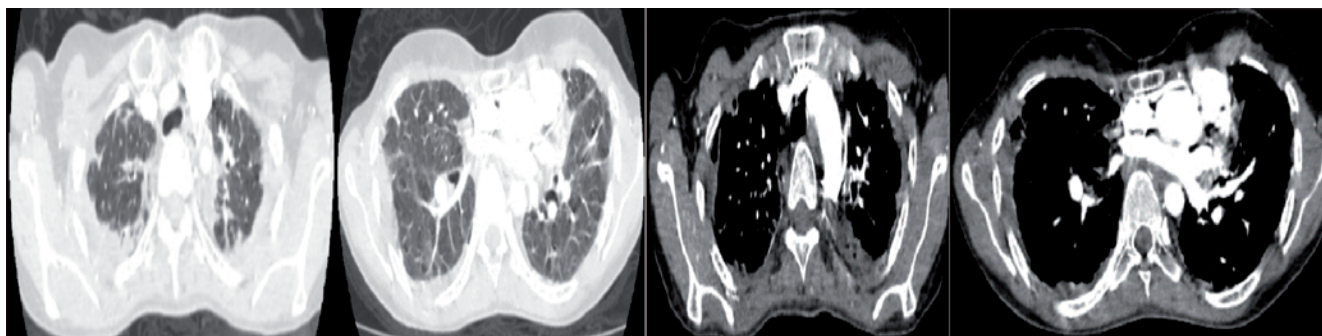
Thorax CT revealing pleural thickening, fibrotic parenchymal lesions involving both upper lung zones, ground-glass infiltrations, bronchiectasis and platythorax.
